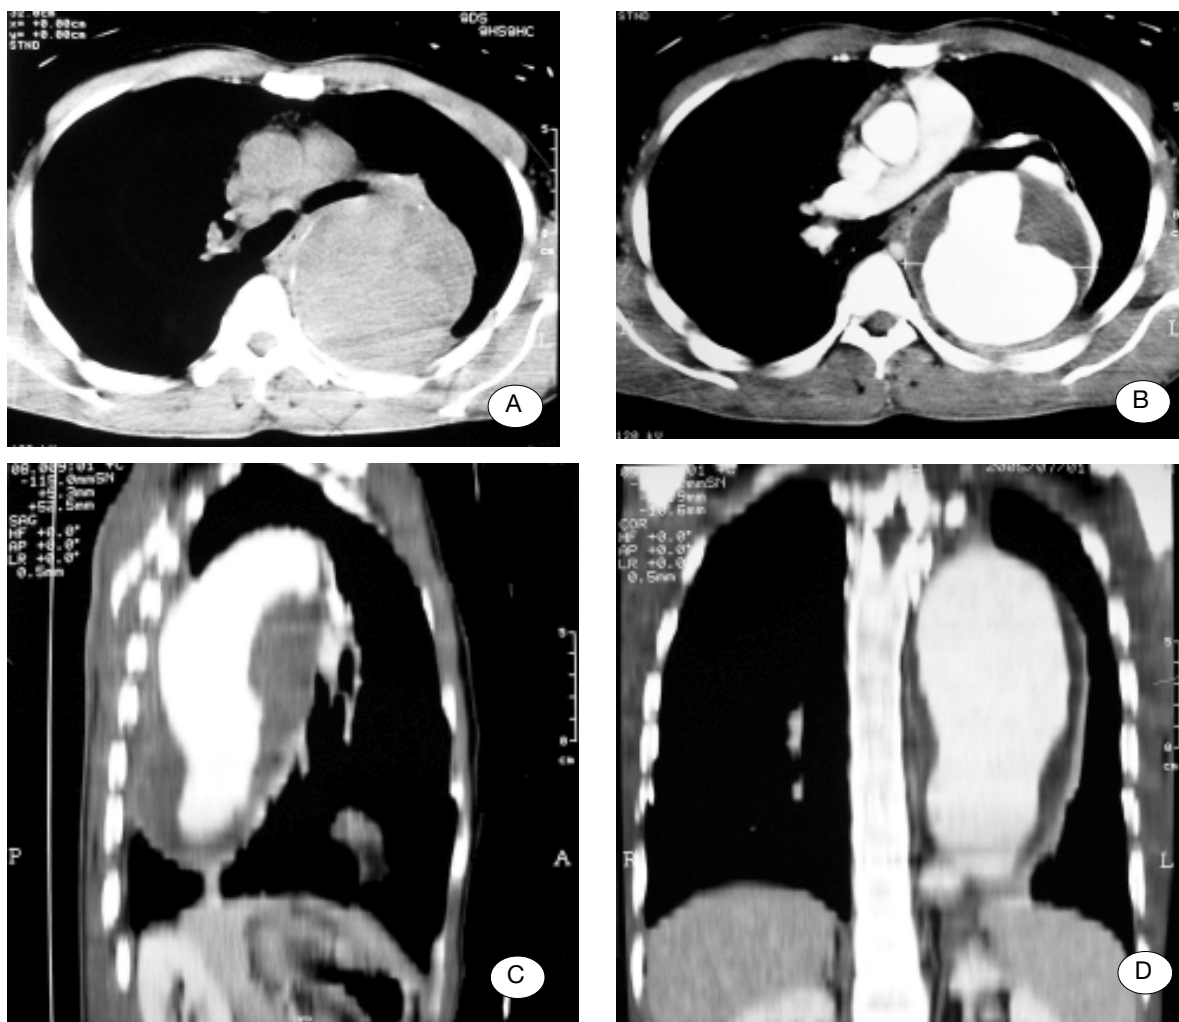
A, B, C and D. Follow up CT scan with contrast enhancement (in this admission) left pleural effusion is disappeared. Minimal pleural thickening adjacent aneurysm is observed without evidence of rupture. Slight increased aneurysmal diameter.
